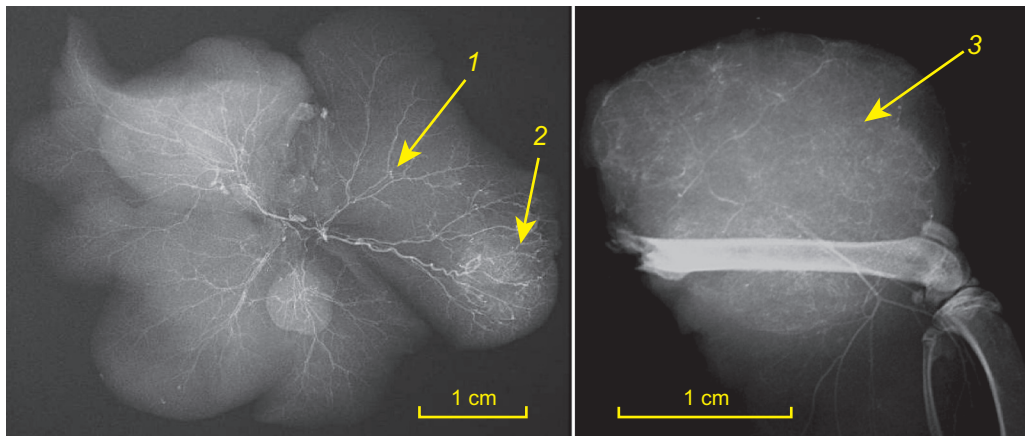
Selective X-ray angiography of normal liver (1), intrahepatic HCC (2), and subcutaneous HCC (3). Barium suspension was injected into the heart by syringe
